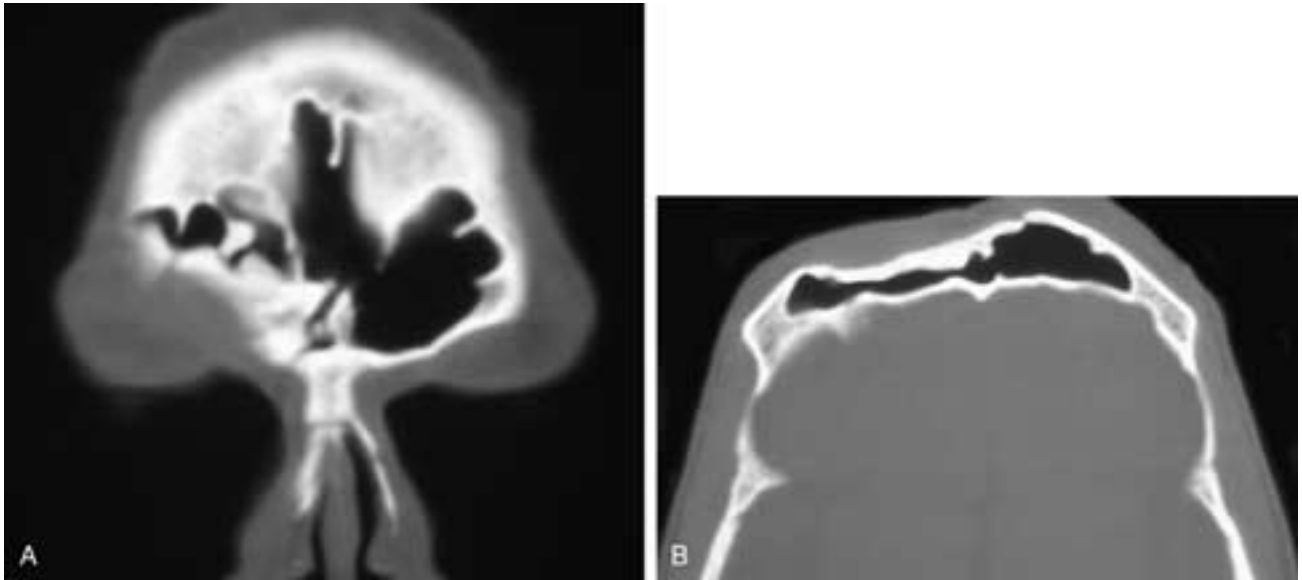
Coronal (A) and axial (B) CT scans show a depressed comminuted fracture of the right anterior frontal sinus table that also involves the right orbital roof.
